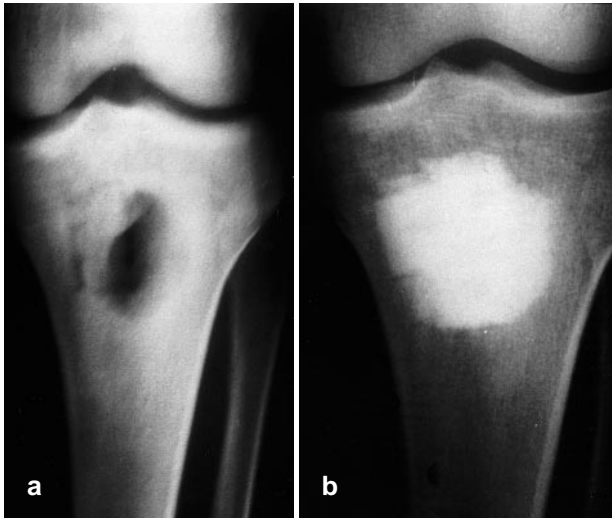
a Radiograph showing a chronic osteomyelitic cavity in the proximal end of a tibia before treatment, and (b) five years after management by the method described in this article. The ceramic blocks appear to be incorporated into bone which has formed and remodelled around them. There is no evidence of translucency which might be suggestive of either infection or the presence of a fibrous membrane
